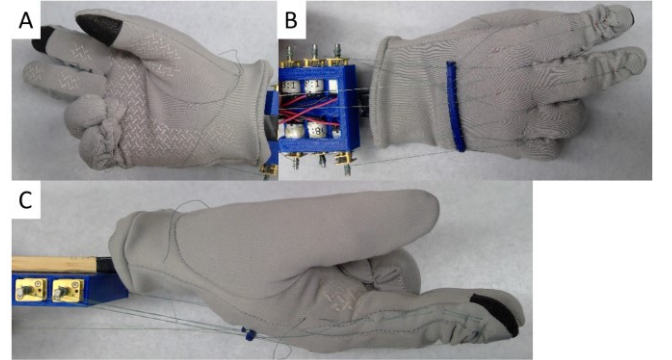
EXTENSION TEST OF THE INDEX AND MIDDLE FINGER WITH THE BOTTOM, TOP, AND SIDE VIEW SEEN IN (A), (B), AND (C) RESPECTIVELY.
